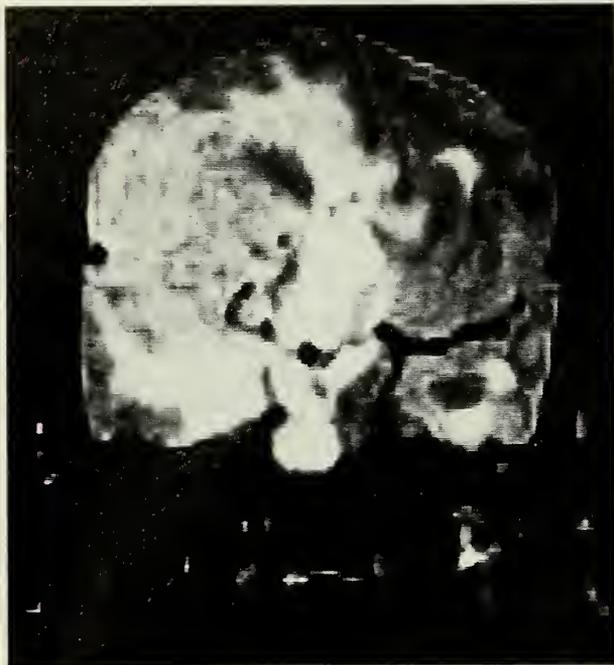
Temporolimbic tumor.* Patient 5 had auditory and visual hallucinations from presumed primary psychiatric disease for an indefinite length of time before being studied radiologically. This T2-weighted coronal magnetic resonance imaging scan, hampered by movement artifact, shows the massive right temporolimbic oligodendroglioma with additional high signal intensity in the frontoparietal areas thought to represent edema (TR = 3.0 sec, TE = 40 msec).
